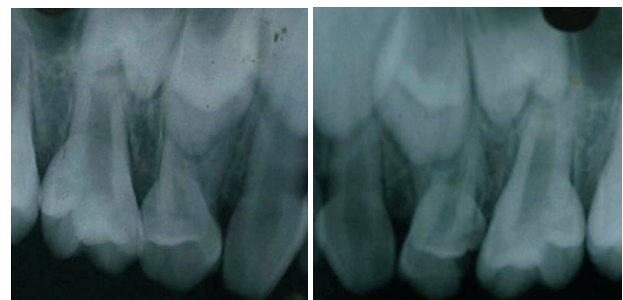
Upper Molar Radiographs
